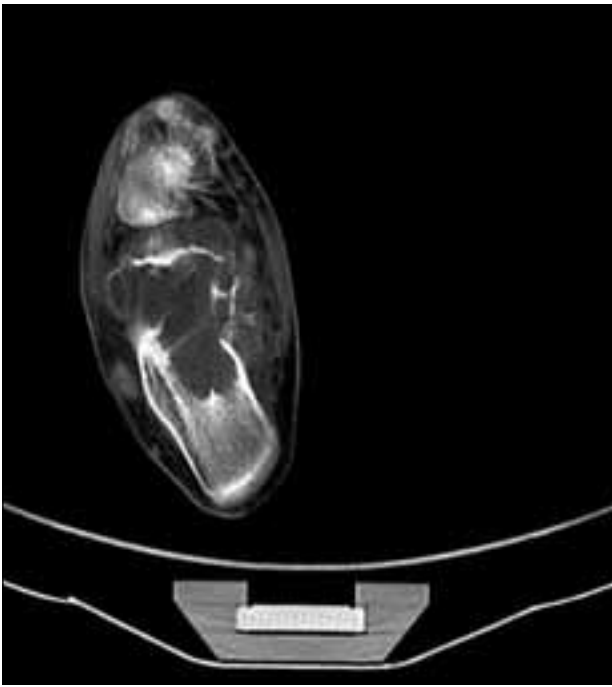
Axial CT image demonstrating aneurysmal bone cyst with bony involvement.
